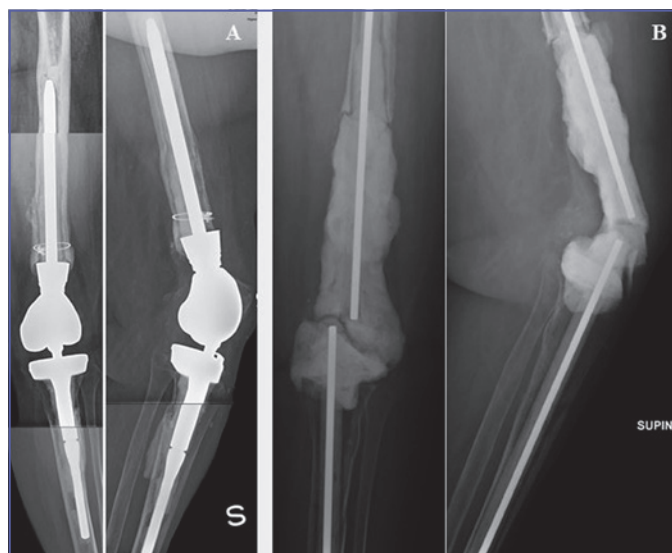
A) preoperative X-ray analysis; B) Antibiotic-loaded static spacer.
